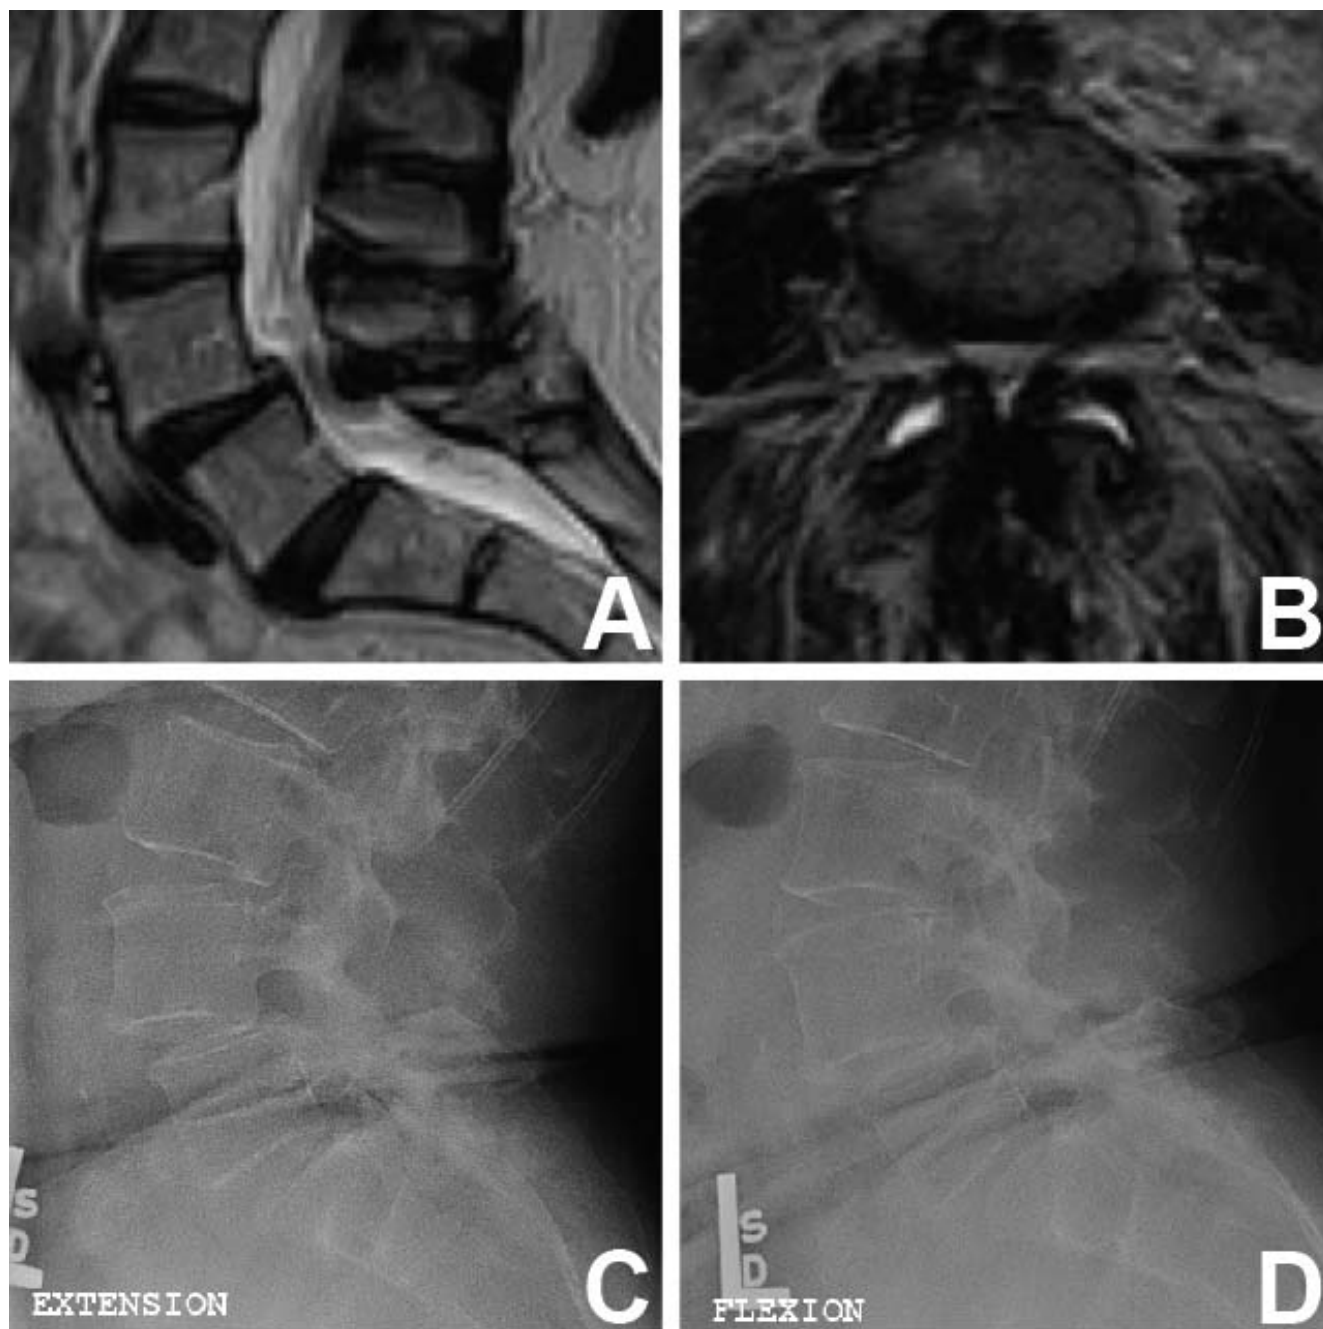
Typical imaging findings in the patients included in our series. (A) Sagittal T2-weighted magnetic resonance imaging (MRI) showing L4-L5 spinal canal stenosis and grade 1 spondylolisthesis of L4 over L5. (B) Axial T2-weighted MRI of the same patient through L4-L5 showing spinal canal and bilateral foraminal stenosis with facet hypertrophy and thickened ligamentum flavum. Extension (C) and flexion (D) radiographs of the same patient showing no dynamic change in the degree of spondylolisthesis.
